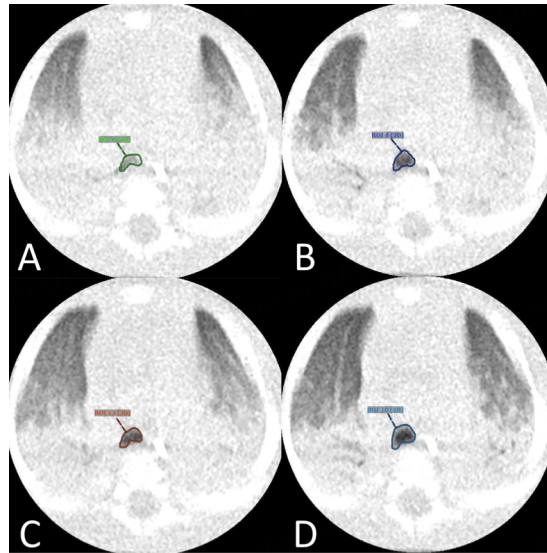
Images from a CT scan of the chest of the incident patient with dynamic evaluation of the airways at 3 months of age before closure of the ductus arteriosus. There was a minimum transverse area of 25.2 mm² (A) and a maximum transverse area of 33.2 mm²; (B) of the lower trachea with a positive end-expiratory pressure of 4 cm H₂O. There was a minimum transverse area of 30.3 mm²; (C) and a maximum transverse area of 47.3 mm²; (D) of the lower trachea with a positive end-expiratory pressure of 12 cm H₂O.
